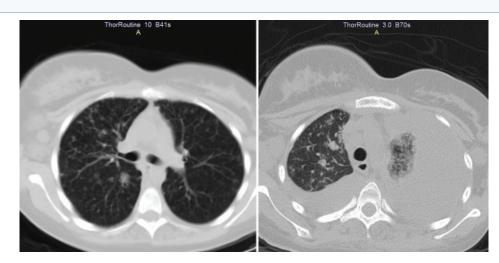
A): Miliary mottling in the thorax CT. B): Ten days later the left lung almost collapsed with a massive pleural effusion.
